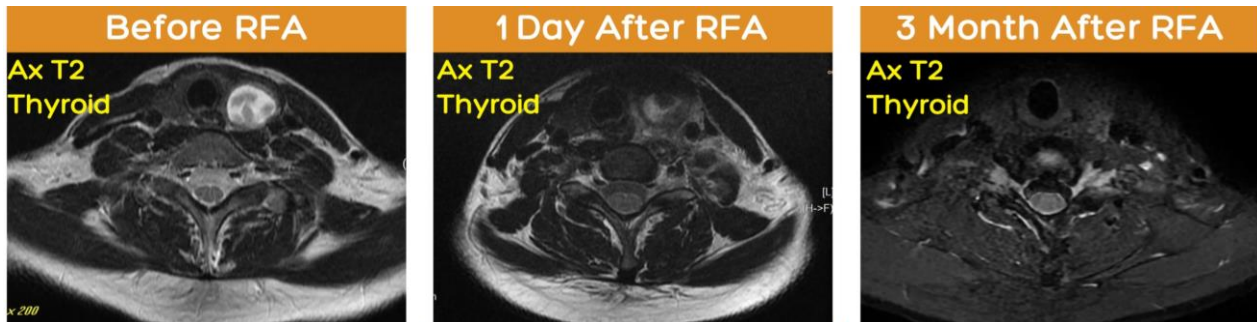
Left thyroid nodule size comparison on MRI. Left: before RFA, size: 17×20 x 29 mm. Middle: 1 day after RFA, size: 14 x 16 x 16 mm. Right: 3 months after RFA, no visible nodule on left thyroid (yellow arrow).
